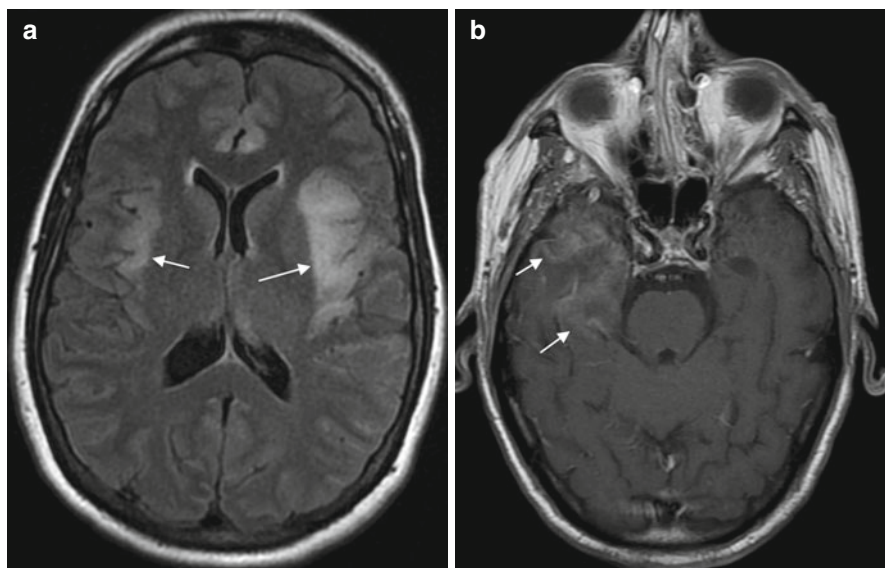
Herpes Simplex Encephalitis. FLAIR image (a) showing asymmetric hyperintensity in the medial temporal lobes, inferior temporal lobes, insular regions and anterior cingulate cortex bilaterally (arrows). T1 post-contrast (b) of a different case demonstrating patchy enhancement in the right temporal lobe (arrows)
